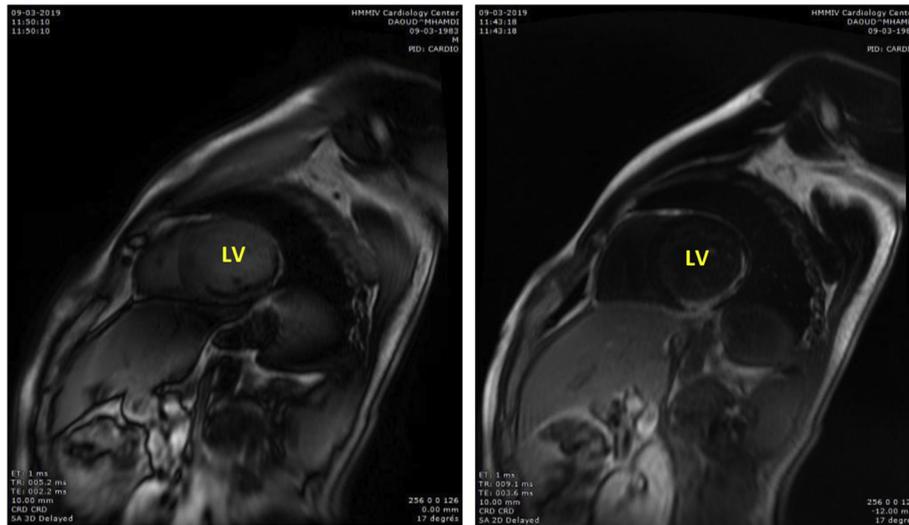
MRI of non-viable inferior and lateral wall infarction. LV = left ventricle.
